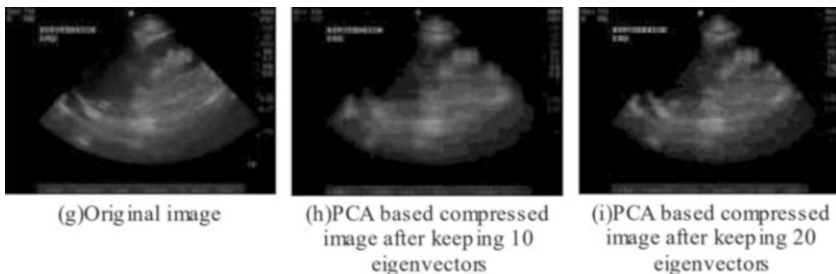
Performance of PCA on ultrasound images (Cao et al. 2017)
